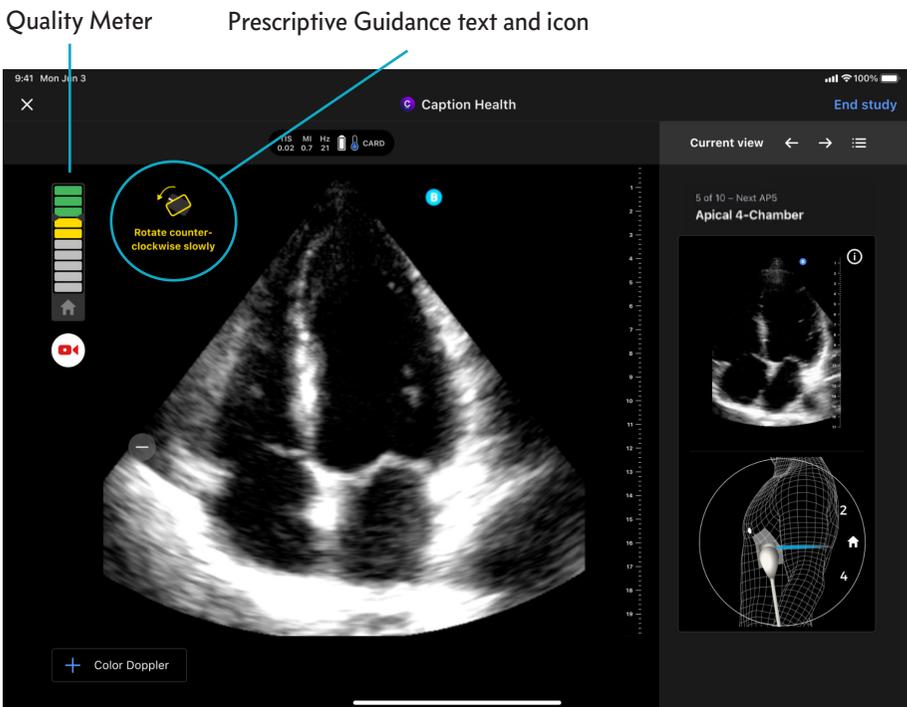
Ultrasound display: real-time guidance
